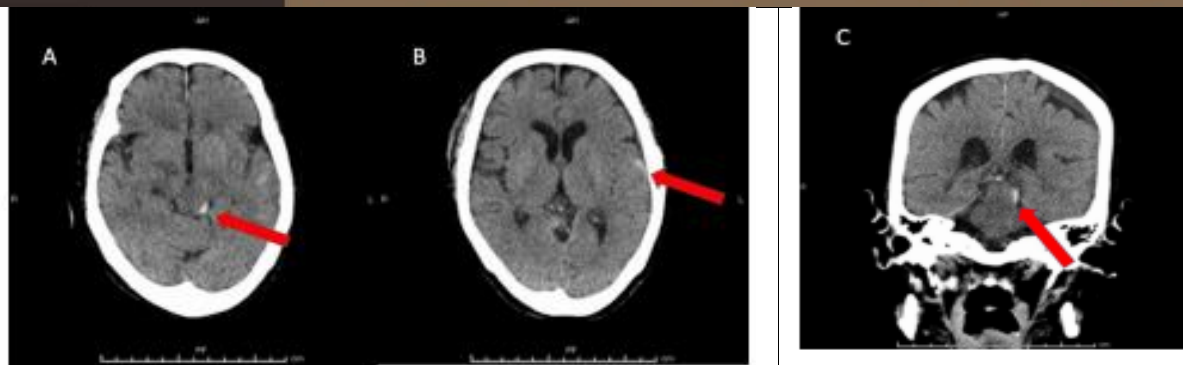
Subarachnoid hemorrhage (SAH) surrounding the midbrain (A) and left temporal lobe (B) as shown on axial computed tomography (CT). SAH and brain contusion are seen on a Coronal CT of the midbrain (C). The lesions are identified by red arrows.
